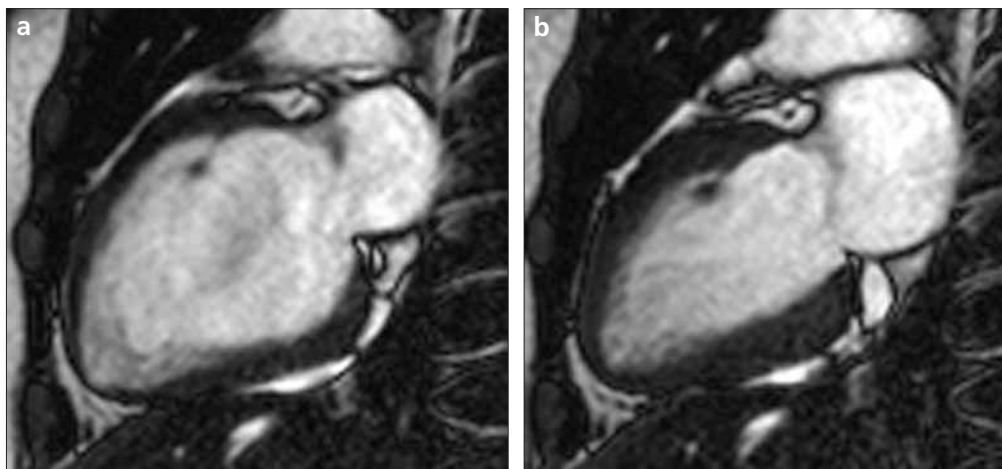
a, b. Vertical long axis multi-segmented cine MR images taken during the end-diastolic phase (a) and the end-systolic phase (b).
